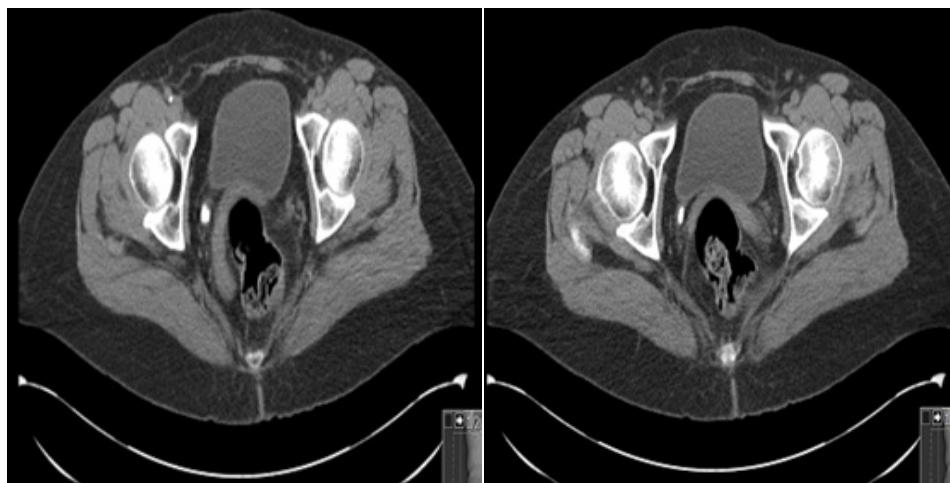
Cross-sectional unenhanced computed tomography showing right ureteric stump stones.
